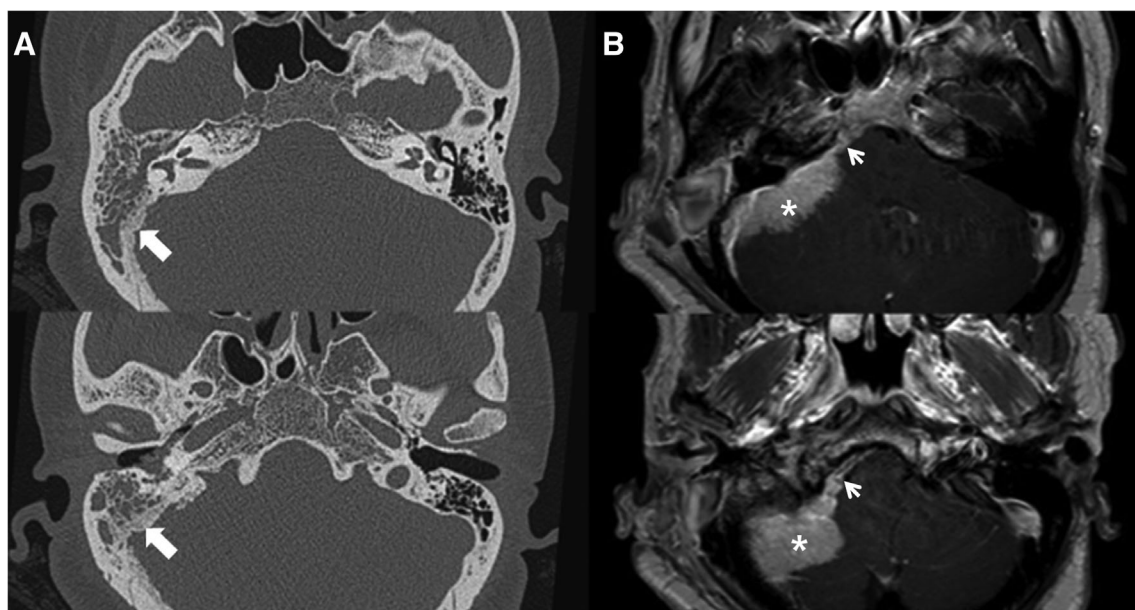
Features of computed tomography imaging in the middle and posterior cranial fossa suggesting the presence of temporal bone meningioma. (A) Diffuse trabecular hyperostosis with irregular margin of the inner surface in middle and posterior cranial fossa (white arrow). (B) The intracranial enhancing mass (white asterisk) with dura tail sign (white arrow head) is identified with magnetic resonance imaging at the matched location of trabecular hyperostosis.
